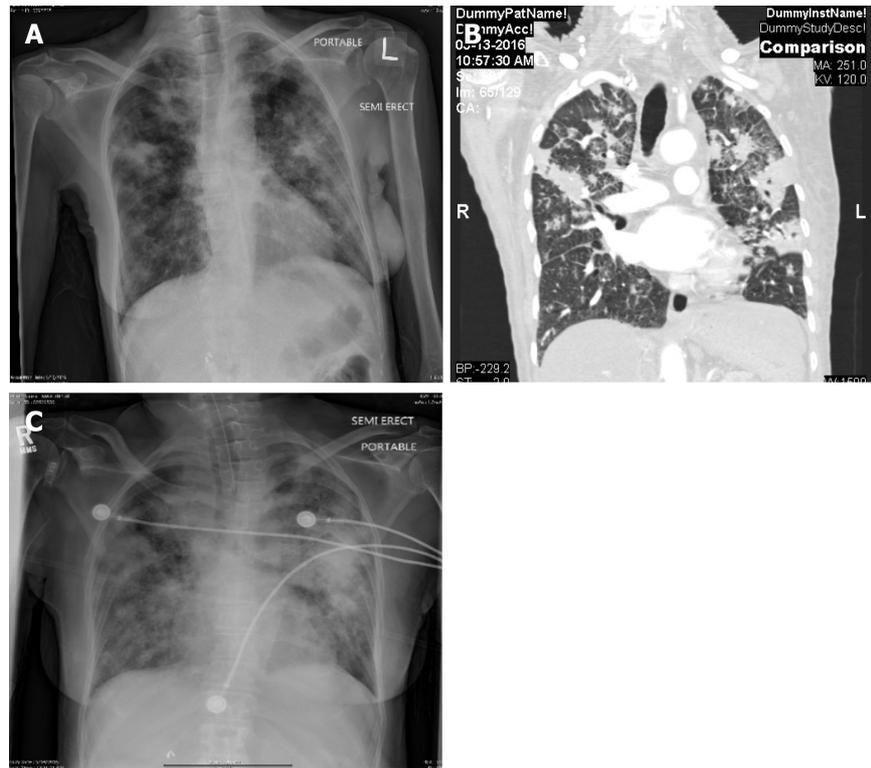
Chest X-ray and computed tomography (case 1). A: Chest X-ray demonstrating the bilateral patchy infiltrates at the time of admission; B: Computed tomography scans of chest with coronal section demonstrating bilateral patchy infiltrates at the time of admission; C: X-ray chest demonstrating worsening of the bilateral infiltrates after intubation and initiation of anti tuberculosis medications.
